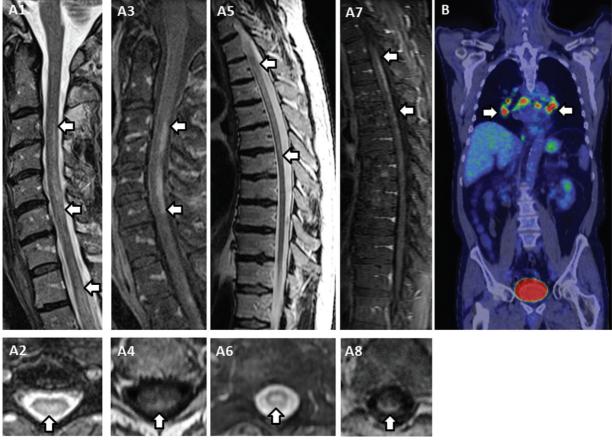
MRI features of spinal cord sarcoidosis. (A) Sagittal T2-weighted and post-gadolinium T1-weighted cervical and thoracic spine MRIs; (B) FDG-PET. Sagittal MRI reveals two separate longitudinally extensive T2-hyperintensities extending at least 3 vertebral segments in the cervical and thoracic spine (A1, A5: arrows) that involve the central cord on axial T2 images (A2, A6: arrows). There was accompanying linear dorsal subpial enhancement (A3, A7: arrows) that involved the dorsal subpia alone on axial images in the cervical cord (A4, arrow) but in the thoracic cord involved the dorsal subpia and central cord forming a three-pronged appearance consistent with an axial "trident sign" (A8, arrow). FDG-PET revealed multiple hypermetabolic (red color) lymph nodes in the hilar region (B, arrows).
